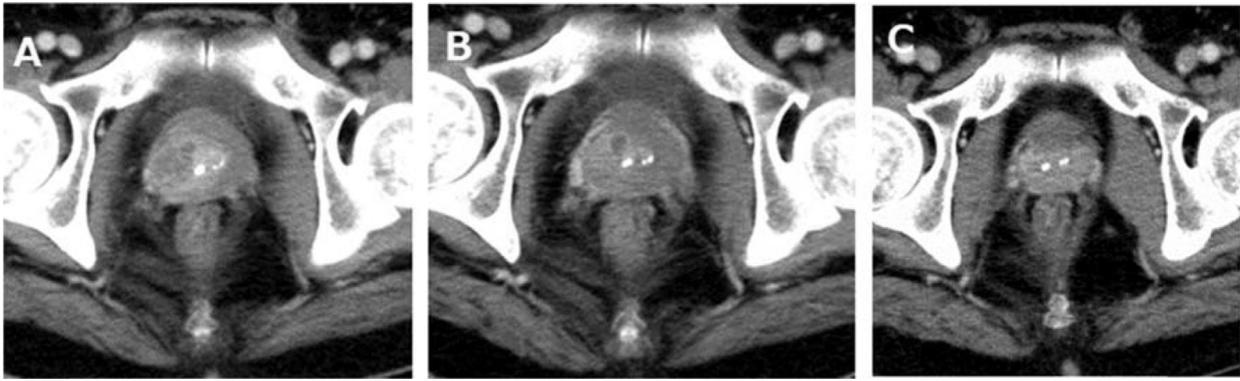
A: Enhanced computed tomography (CT) on day 5 demonstrates a ring enhancing lesion within the prostate. B: Follow up CT performed on day 12 reveals reduction of the prostate abscess. C: On day 52, the prostate abscess was absent on the follow up CT.
